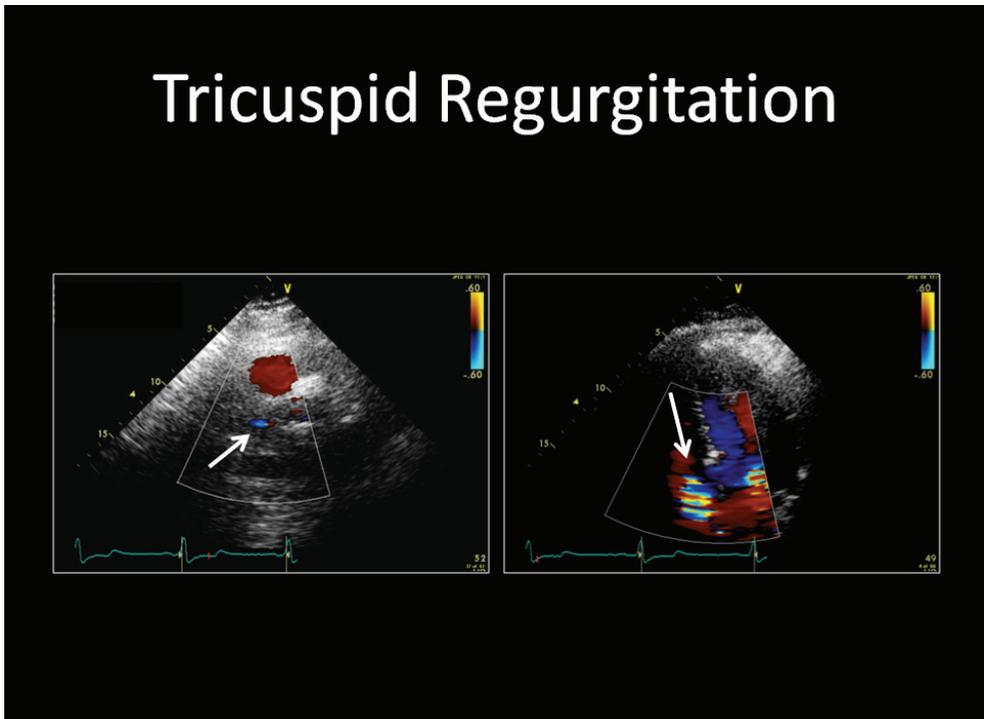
Color flow Doppler display of tricuspid regurgitation (TR). Left. Unenhanced systolic image with very weak color flow demonstrating minimal TR (arrow). Right. Contrast enhanced image with gains set at zero to minimize noise artifact. Note the enhanced systolic color flow Doppler signal (arrow) allowing for an increased likelihood to measure the conventional spectral Doppler tracing
